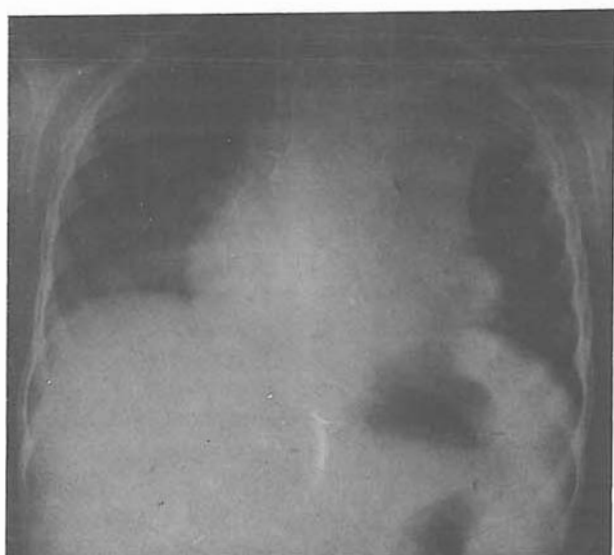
Postoperative chest roentgenogram taken seven weeks after surgery revealing good lung expansion and complete resolution of mass.
